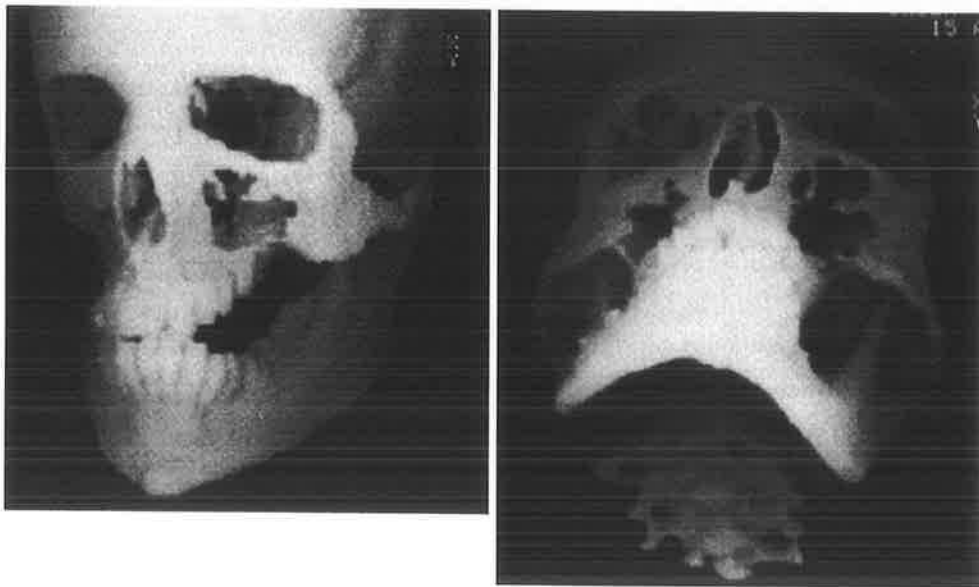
A. Oblique and B. worms eye 3-D CT reformats expose the skeletal anatomy of the orbitozygomatic, midface, and mandibular deformities.
